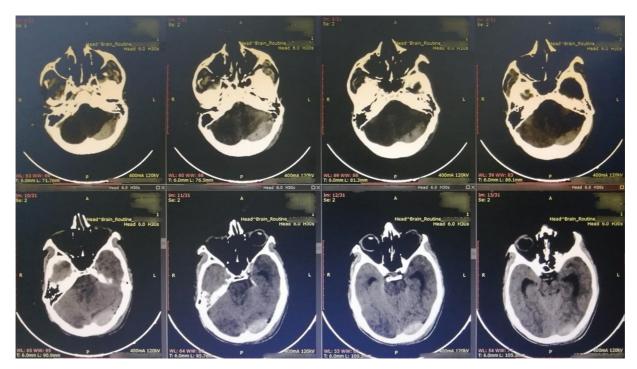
Preoperative axial computed tomography brain plain showing left-sided occipital and posterior fossa epidural hematoma.
